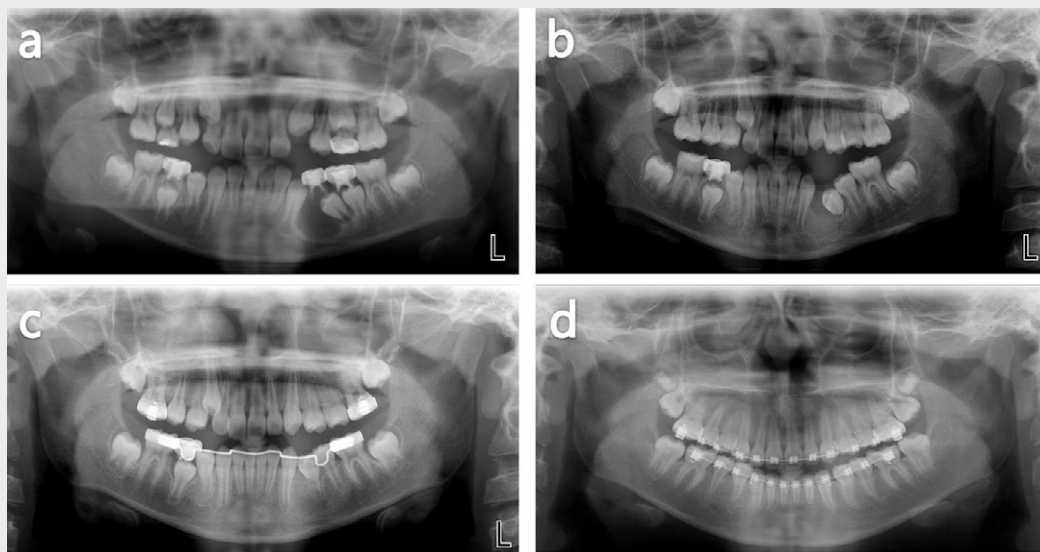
Panoramic X-rays of case 2.
